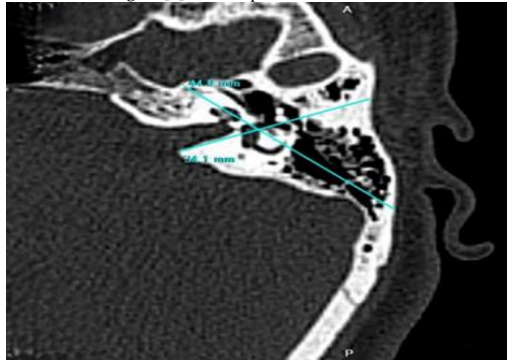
CT Temporal Bone Axial view
